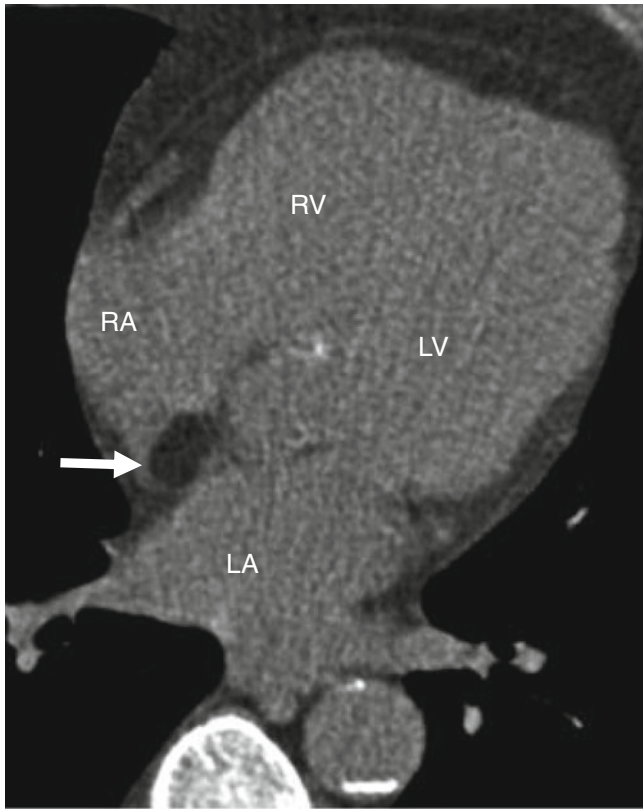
Cardiac Lipoma. A noncontrast axial CT scan demonstrating a well-defined focal fat-containing lesion (*arrow*) along the right atrial wall. *LA* left atrium, *RA* right atrium, *LV* left ventricle, *RV* right ventricle
